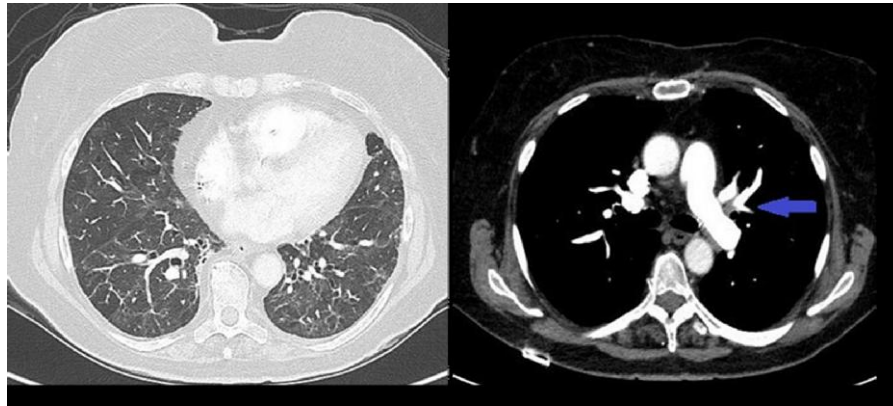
Computed tomography scan of the chest showing prominent broncho-vascular markings and bronchiectasis changes in the basal lung fields (left) and branch pulmonary artery emboli (right, arrow).
